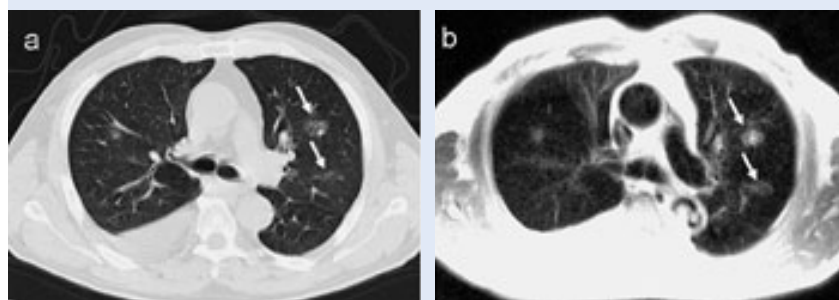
Small irregular infiltrates in immunosuppressed patient. Multi-detector HR-CT (a) and iPAT HASTE MRI (b).
